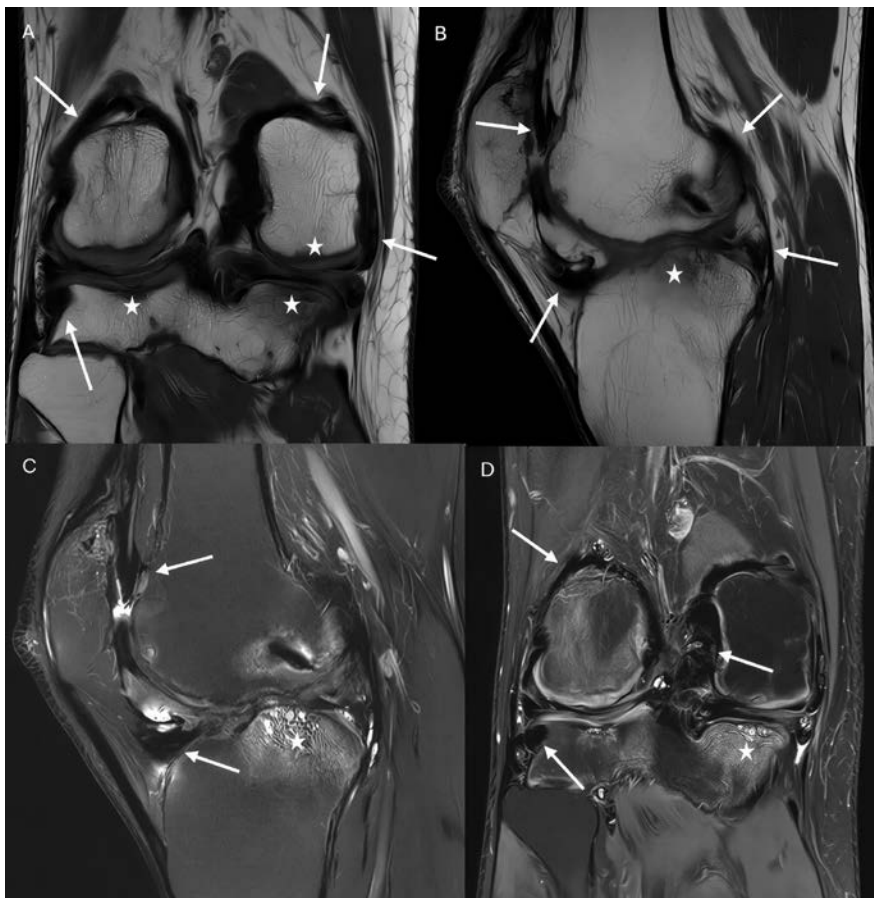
Coronal T1-weighted (A) and sagittal PD images (B) demonstrate diffuse synovial thickening with predominantly low signal intensity (arrows), associated with irregular articular surfaces and subchondral changes (stars). PD-FS (C) and T2-weighted FS images (D) show hypointense synovial hypertrophy (arrows), and bone marrow oedema (stars). Marked low-signal synovial deposition on all sequences reflects extensive hemosiderin accumulation due to recurrent hemarthroses. Although the low signal and hemosiderin deposition may mimic TSGCT, the diffuse joint involvement, advanced degenerative changes, and the known clinical history of haemophilia strongly support haemophilic arthropathy.
